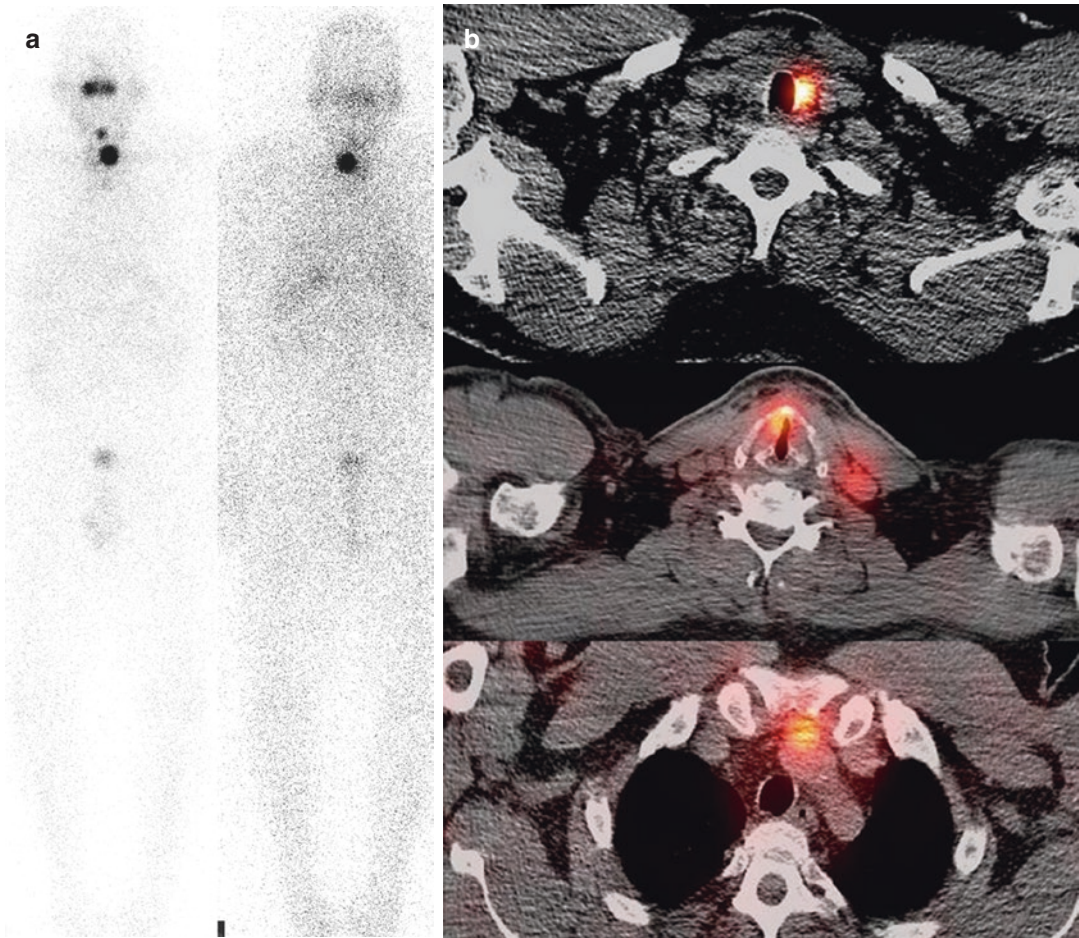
A 60-year-old man with postablation scan for follicular carcinoma localized to the thyroid. TBI (a) with SPECT (b) shows spread to local nodes in the neck and chest
